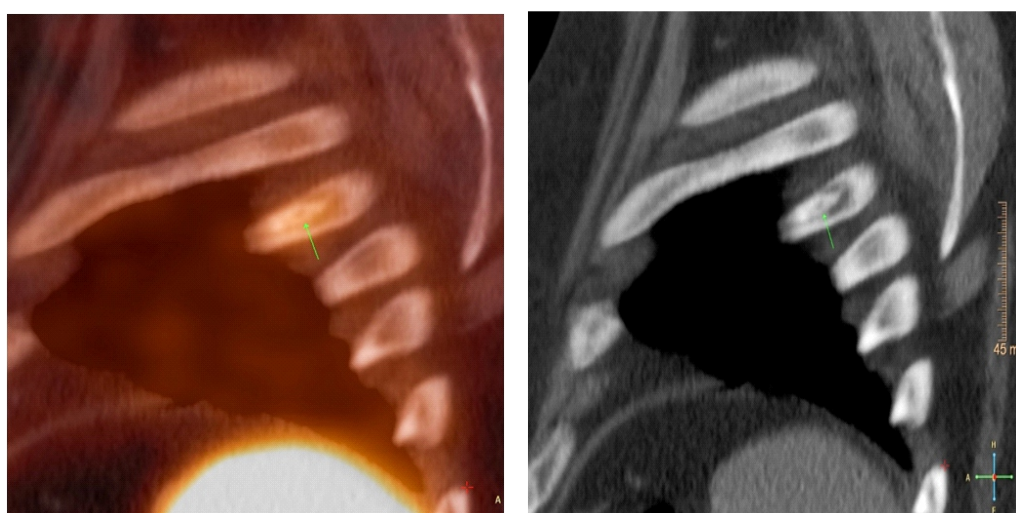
Gallium-68-PSMA-11 PET/CT transverse fused images and a CT images of a patient with a PSMA positive discrete osteosclerotic lesion in left iliac bone and 7<sup>th</sup> rib on the right.
